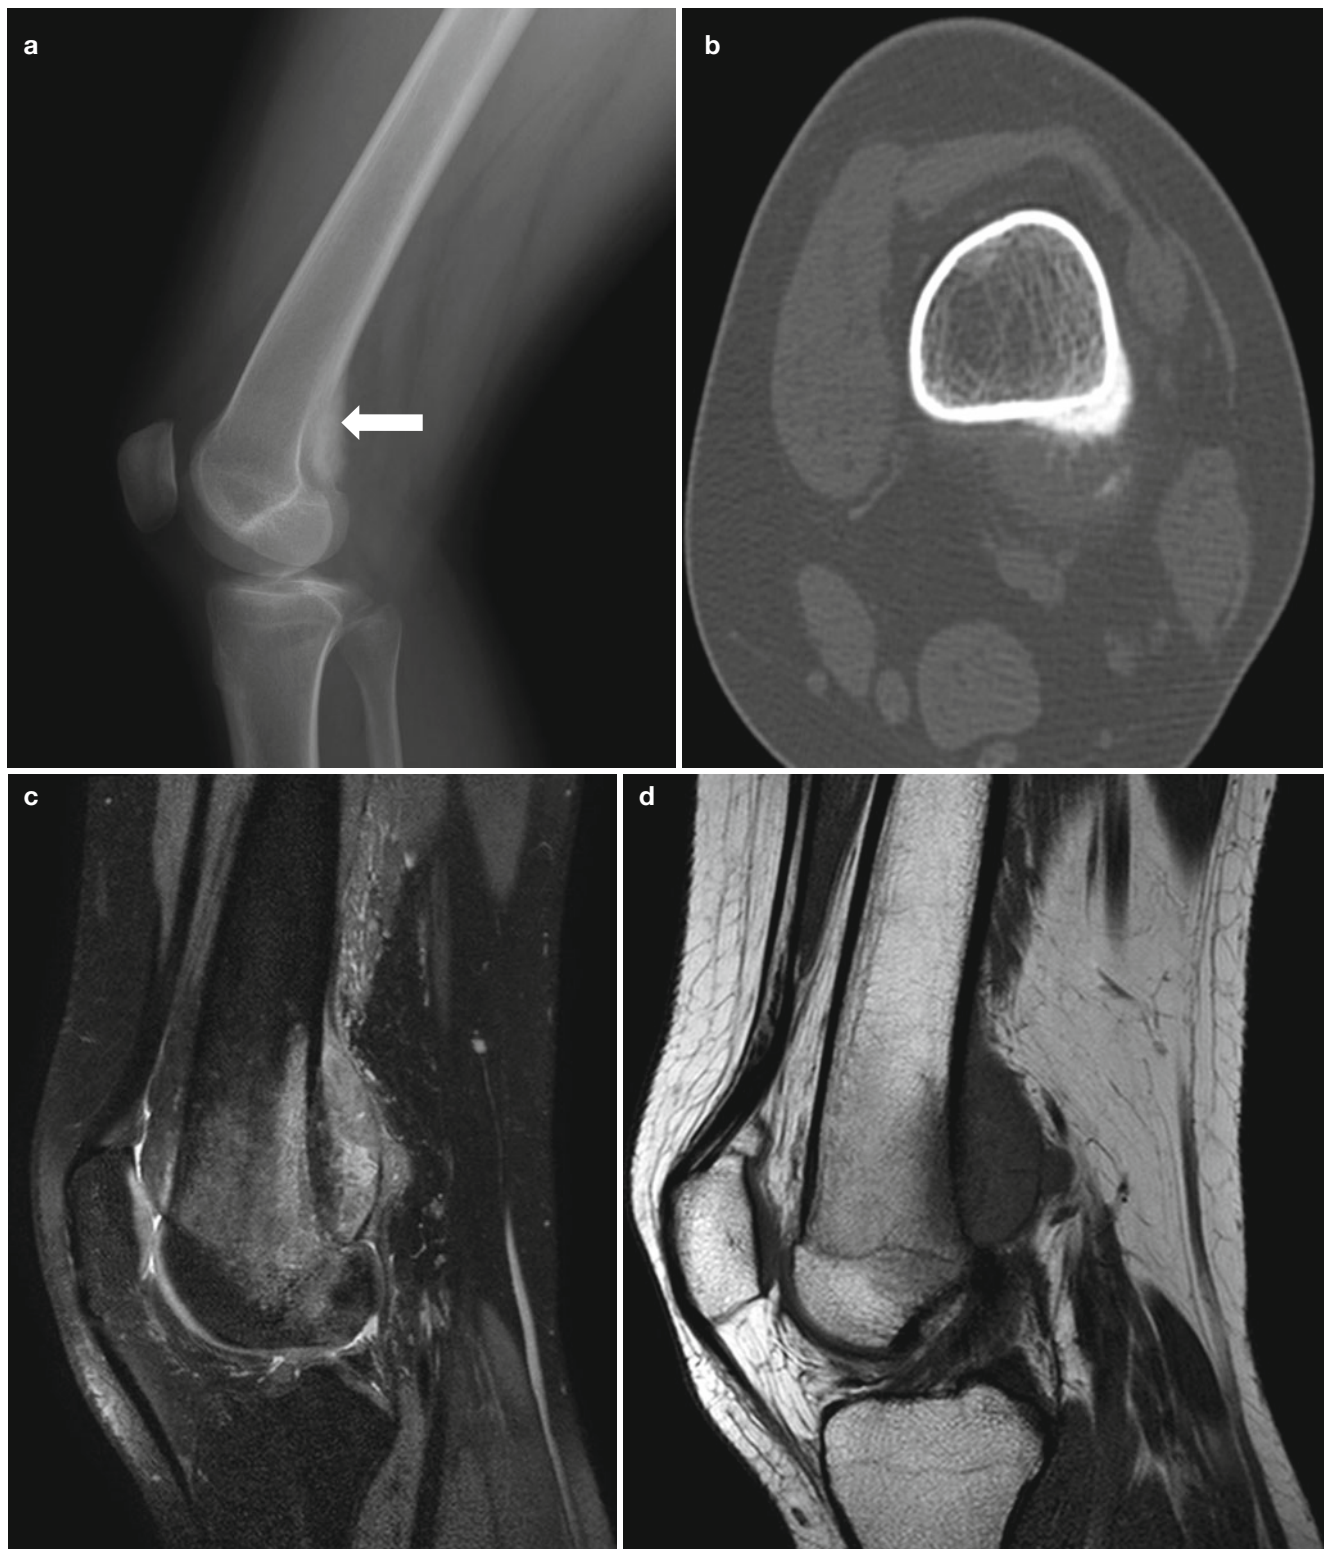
Presumed juxtacortical or periosteal osteosarcoma in a 15-year-old girl. (a) Densely ossified lesion is seen along the posterior cortex of the left distal femur (arrow). (b) Axial CT scan shows a juxtacortical soft tissue mass with ossifications along the posterolateral cortex of distal femur. (c, d) Fat-suppressed proton-density VISTA
